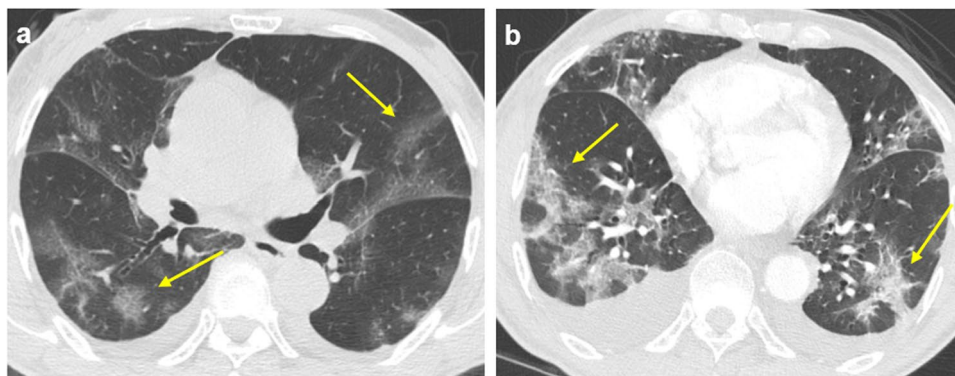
Seventy-nine-year-old male with a history of ER+, PR+, HER2- grade 3 invasive ductal carcinoma of the breast presenting to the emergency department with shortness of breath and positive COVID-19 status. a Axial non-contrast CT image of the chest demonstrates multifocal patchy bilateral ground glass opacities with peripheral predominance (arrows), as well as trace bilateral pleural effusions. These findings were deemed consistent with the patient's diagnosis of COVID-19 pneumonia. b A repeat non-contrast CT scan was obtained 3 days later when the patient presented again to
